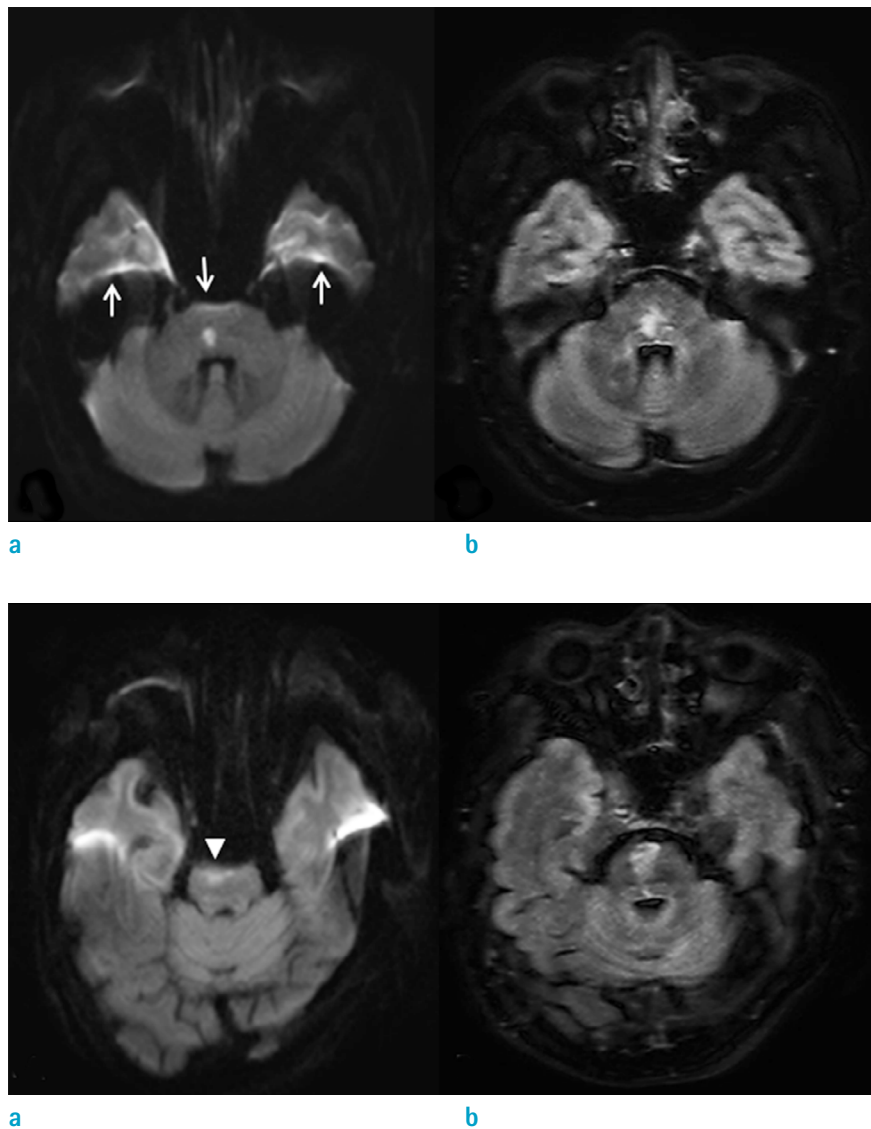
Examples of two patients with infratentorial infarctions, for qualitative assessment of image quality in each sequence. Top row: An age 50 male who underwent magnetic resonance imaging (MRI) scan at 20 hours after left ataxia. A typical susceptibility artifact (white arrows) is visible on (a) diffusion-weighted imaging (DWI), without affecting diagnosis of a small (< 2 cm) hyperintense lesion in the right pons (Score 2). In (b) double inversion recovery (DIR), a lesion is identified at a location corresponding to that of DWI, without anatomic distortion (Score 3). Bottom row: Images of an age 81 female presenting left side weakness and speech disturbance, were obtained within 48 hours after symptom onset. (a) DWI shows considerable geometric distortion by susceptibility artifact, leading to underestimation of right paramedian pontine infarction (arrowhead) (Score 1). Also, itself may be mistaken for an artifact. In contrast, (b) DIR shows definite high signal intensity lesion in the right pons (Score 3).
